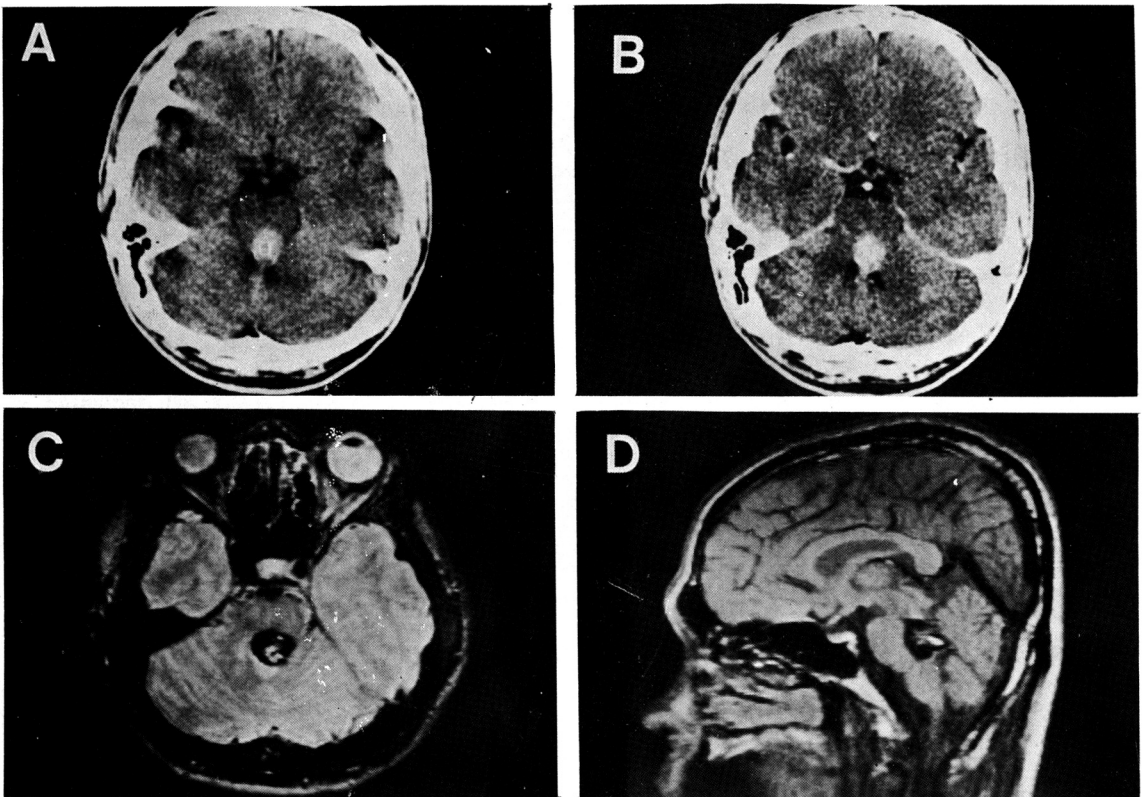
Cryptic vascular malformation. A, Unenhanced axial CT scan demonstrates hyperdense pontine lesion with little mass effect. B, Axial CT scan with IV contrast. C, Axial T2-weighted image (TR=2,000 ms, TE=60 ms) shows a hypointense periphery and the *variably* isointense center in the brainstem. D, Sagittal T1-weighted image (TR=500 ms, TE=30 ms) localizes the lesion in the Guillain-Mollaret' triangle.
